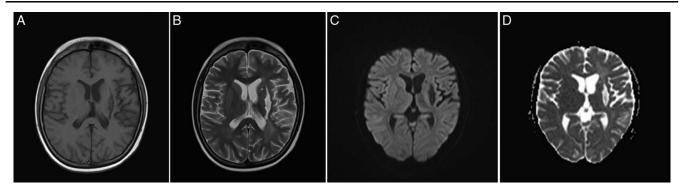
(A,B) MRI, 10 days after thrombectomy showed basal ganglia hypointensity in T1 and hyperintensity in T2 weighted images in favor of encephalomalacia. (C, D) There is no evidence of restricted diffusion in ADC and DWI images, respectively. ADC, apparent diffusion coefficient; DWI, diffusion weighted imaging.
